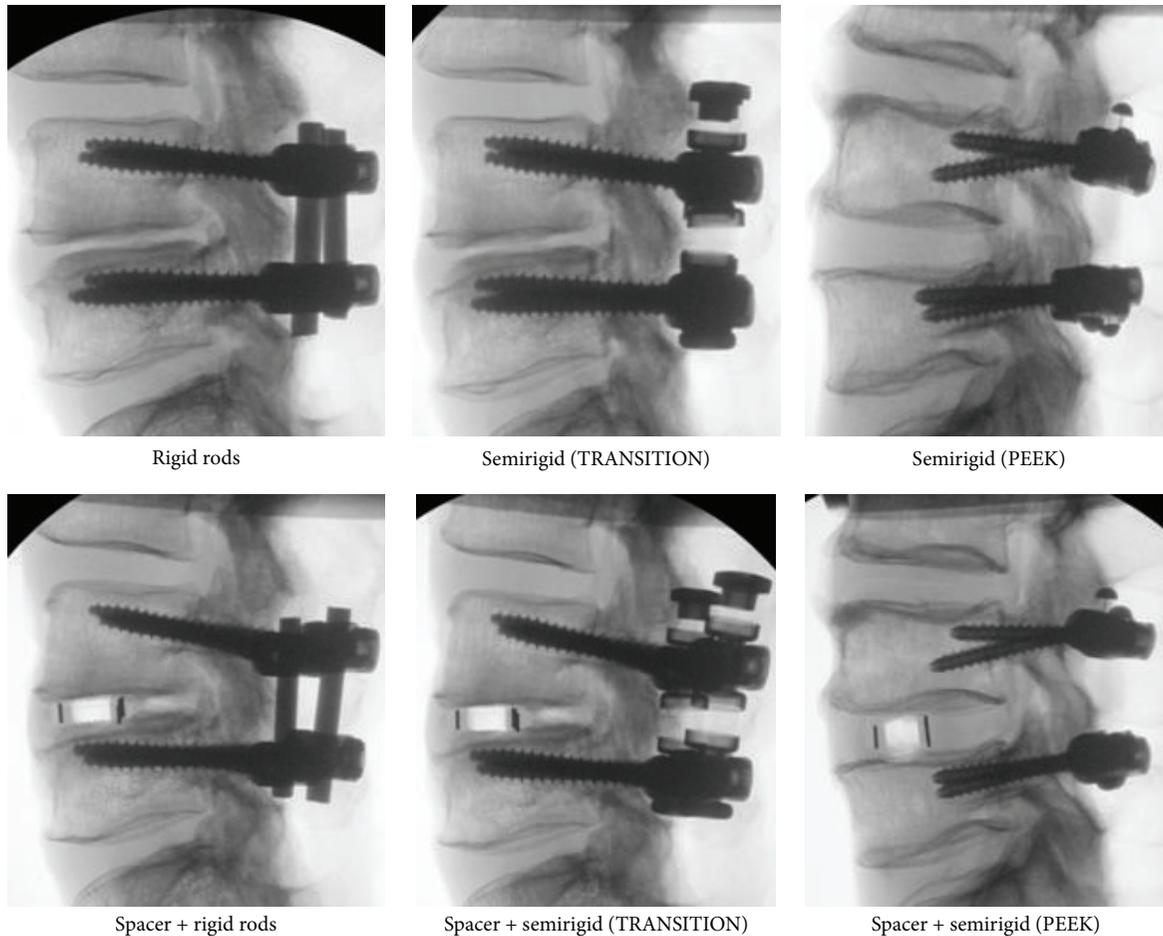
Select radiographs from flexibility testing, showing rigid and semirigid devices.
